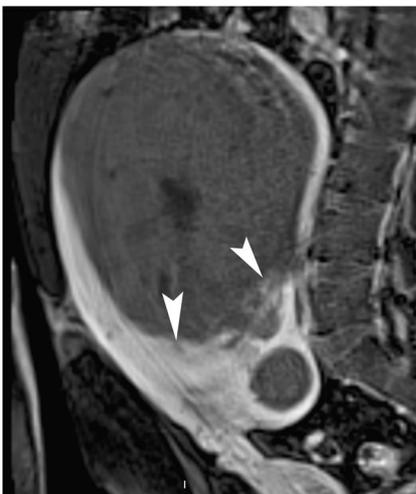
35-year-old woman who had uterine artery embolization (UAE) for symptomatic uterine leiomyomas. Gadolinium chelate-enhanced 3D-VIBE® sequence in the sagittal plane shows almost complete (90–99 %) devascularization of the dominant leiomyoma on the 48-h post-UAE MR imaging with persisting enhancement of less than 10 % of the leiomyoma volume (*arrowheads*)
